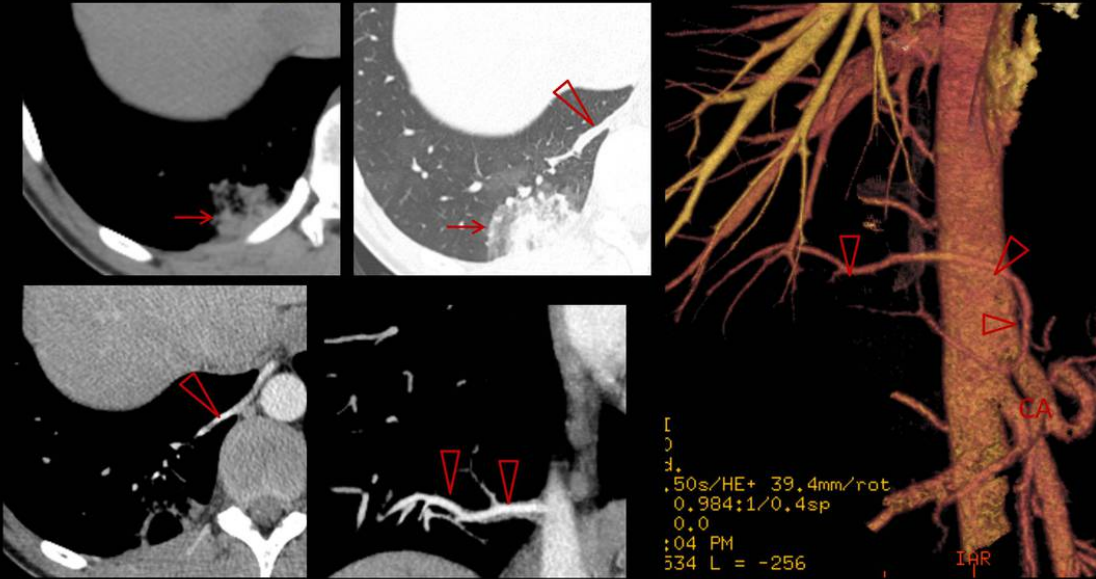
33 year-old patient with recurrent hemoptysis. CT images show a consolidation / mass at the posterior basal segment of the right lower lobe (arrow) with a systemic feeding artery (arrowheads) arising from the abdominal aorta, just adjacent to the celiac axis (CA).
